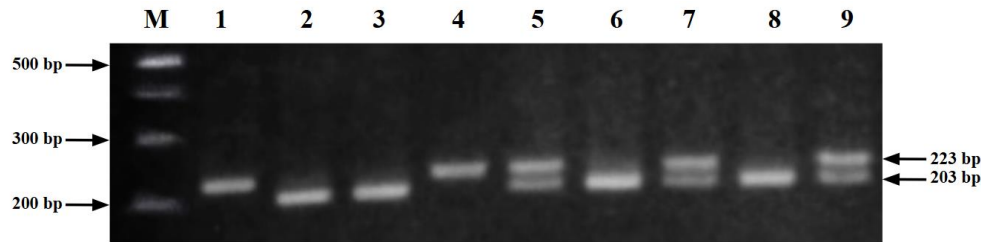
HinfI*-digested PCR products on a 3.7% agarose gel. M: Marker 100 bp, 1: Undigested PCR product; 2, 3, 6, 8: Samples with the CC genotype (2 bands with 203 bp, and 20 bp); 4: Sample with the TT genotype (223bp); 5, 7, 9: Samples with the CT genotype (3 bands with 223 bp, 203 bp, and 20 bp).
